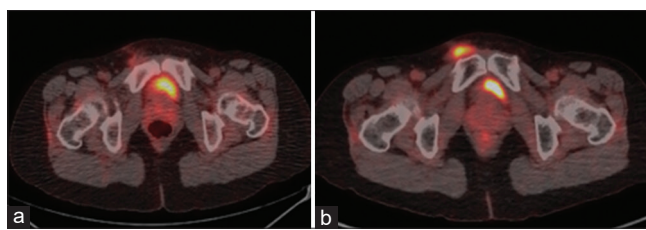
Positron emission tomography/computed tomography (PET/CT) scan at the initial diagnosis and disease recurrence. (a) After wide excision of the tumor, the PET/CT scan only showed mildly increased fluorodeoxyglucose uptake over the right inguinal area, suspected to be due to postoperative inflammation. (b) 3 years after the initial diagnosis, the PET/CT scan showed recurrent tumor lesion
